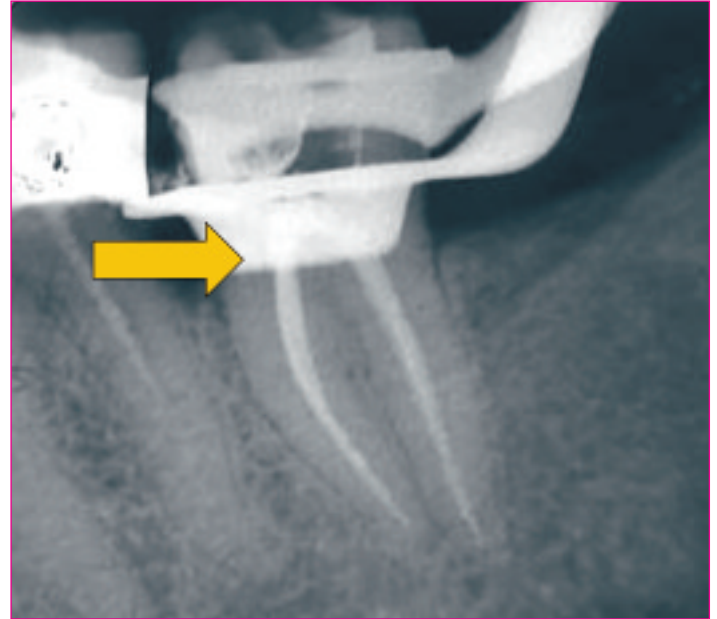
Immediate post-op radiograph showing a more direct access to the apex, which allowed a satisfactory root canal treatment.
